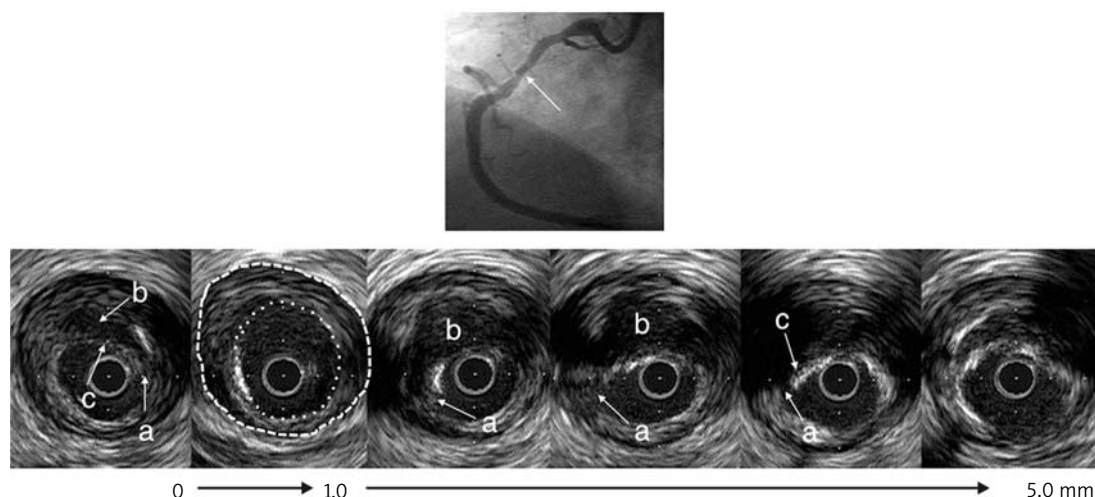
This is an example in which two tears occurred within the same fibrous cap, both at the junction of the fibrous cap and vessel wall. The lesion is shown by the white arrow in the angiogram. The IVUS image shows the two lateral tears in the fibrous cap (“a”), the evacuated cavities (“b”), and the residual fibrous cap fragments (“c”). The two tears are separated by a short segment of artery with an intact fibrous cap where, as in Figure 1, the EEM is indicated by the outer dashed line and the lumen by the inner dotted line (from Mintz GS. Intracoronary Ultrasound. London, Taylor and Francis Group, 2005)
